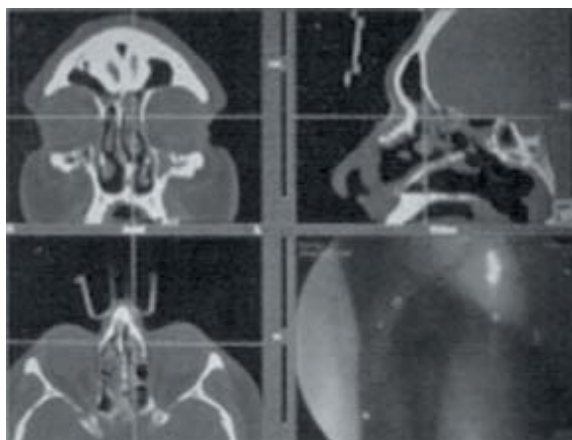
Computer-assisted surgery was initially developed for accurate localization during neurosurgical procedures. The application of this technique in endoscopic sinus surgery is available in many major centers. This system allows the surgeon to localize the tip of the surgical instrument in the paranasal sinuses, generally within 2 mm of accuracy on coronal, axial, and sagittal CT images
